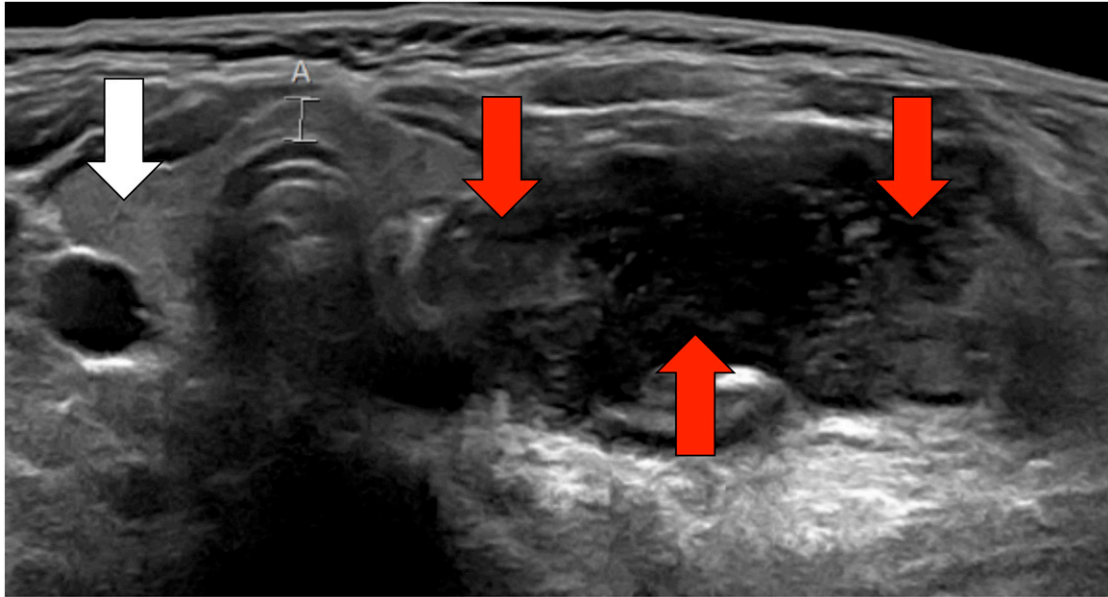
Ultrasound image of large cystic and solid lesion contiguous with the left thyroid lobe, $4.8 \times 3.0 \times 4.8$ cm. White arrow highlights normal thyroid parenchyma. Red arrows highlight abscess.
